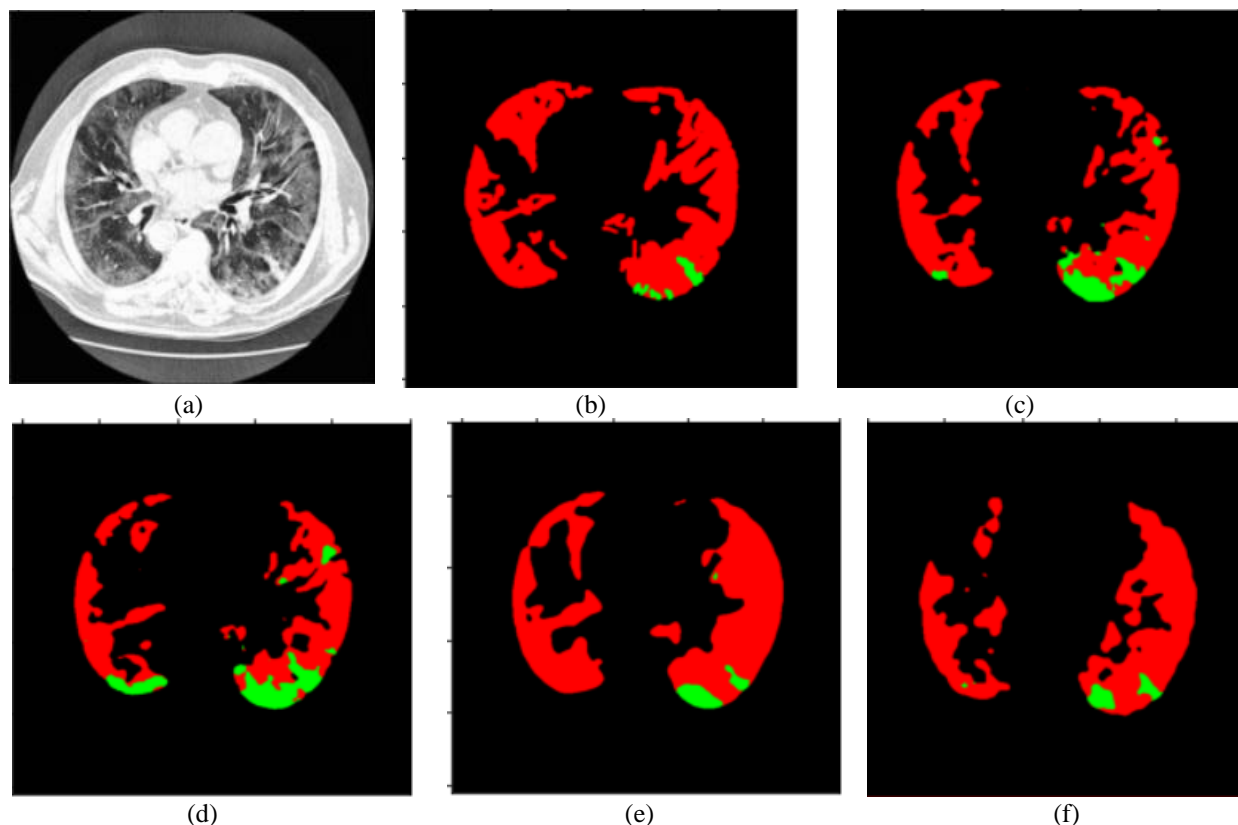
(a) image test CT scan COVID-19, (b) Groundtruth image (c) Resnet+Unet, (d) EfficientNet+Unet, (e) Resnet+SwishUnet, and (f) EfficientNet+SwishUnet
